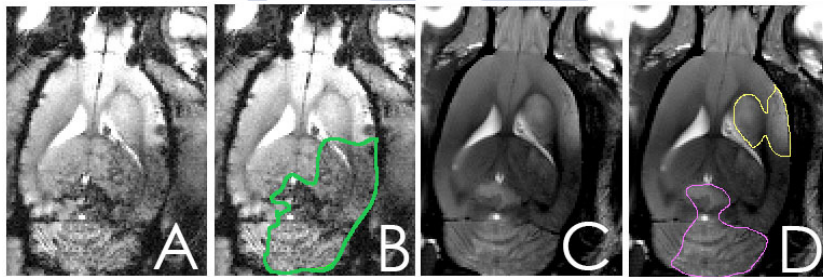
(A) and (B) same slice of the 5th echo of MGE sequence 4h after intra-arterial injection of 1×10^6 labeled MSCs following delivered route condition "c". In (B) hypointense signal produced by labeled cells is delimited in green. (C) and (D) are T_2 weighted MR images of same slice 4h after intra-arterial injection of 1×10^6 labeled MSCs following delivered route condition "c". Yellow line and Pink line in (D) would correspond to ischemic lesion produced by tMCAO and region where labeled cells were found respectively.
